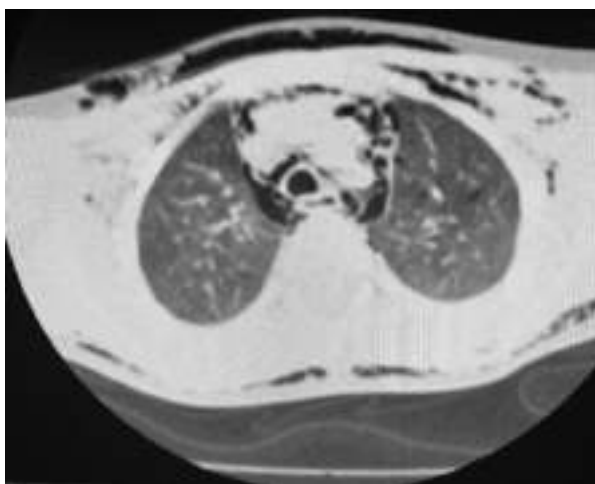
Chest CT shows pneumomediastinum and subcutaneous emphysema
